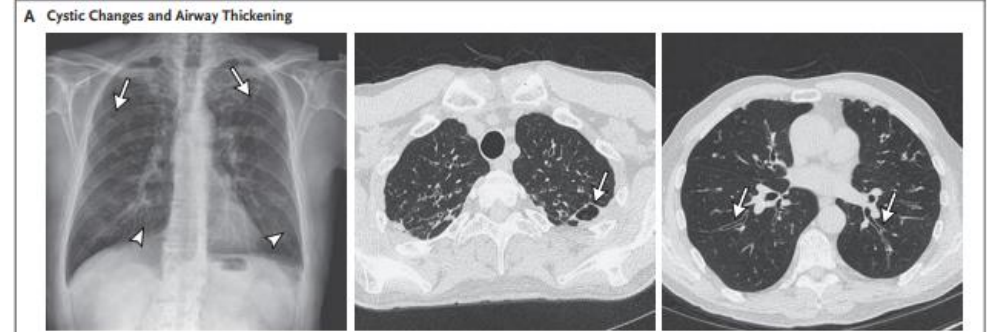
Radiographic Features of Bronchiectasis.
